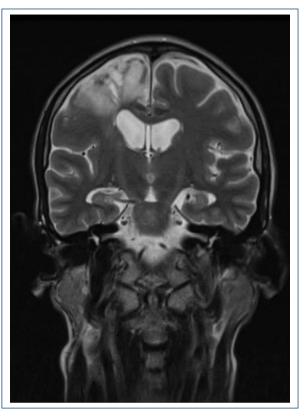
Magnetic resonance imaging shows right frontal leptomeningeal enhancement associated with encephalomalacia.
